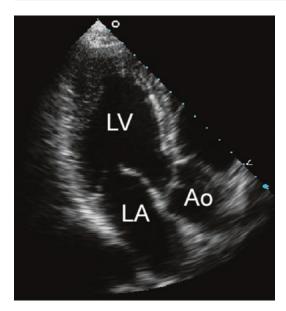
The apical long-axis or three-chamber view demonstrates the same anatomy that is seen in the parasternal long-axis view
